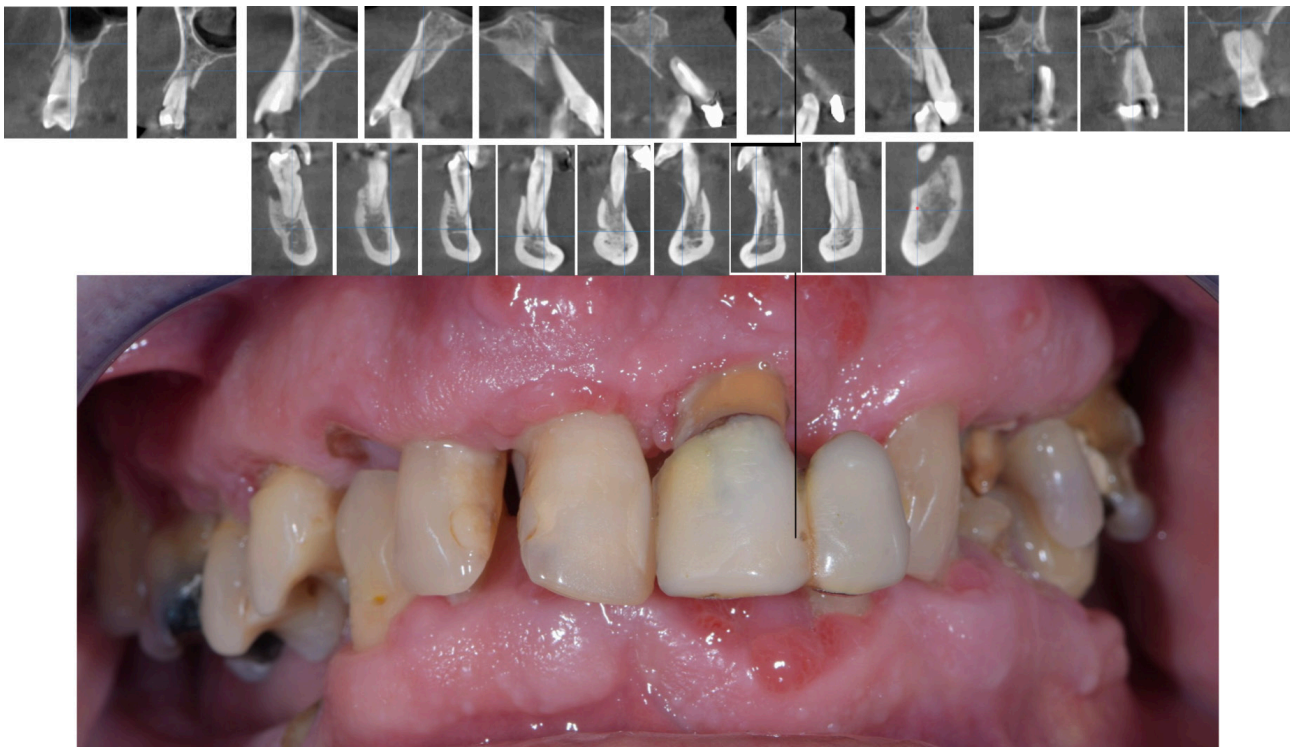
Cone-beam computed tomography (CBCT) cross-section scans (a) and intraoral photography (b) presenting seriously compromised teeth.
